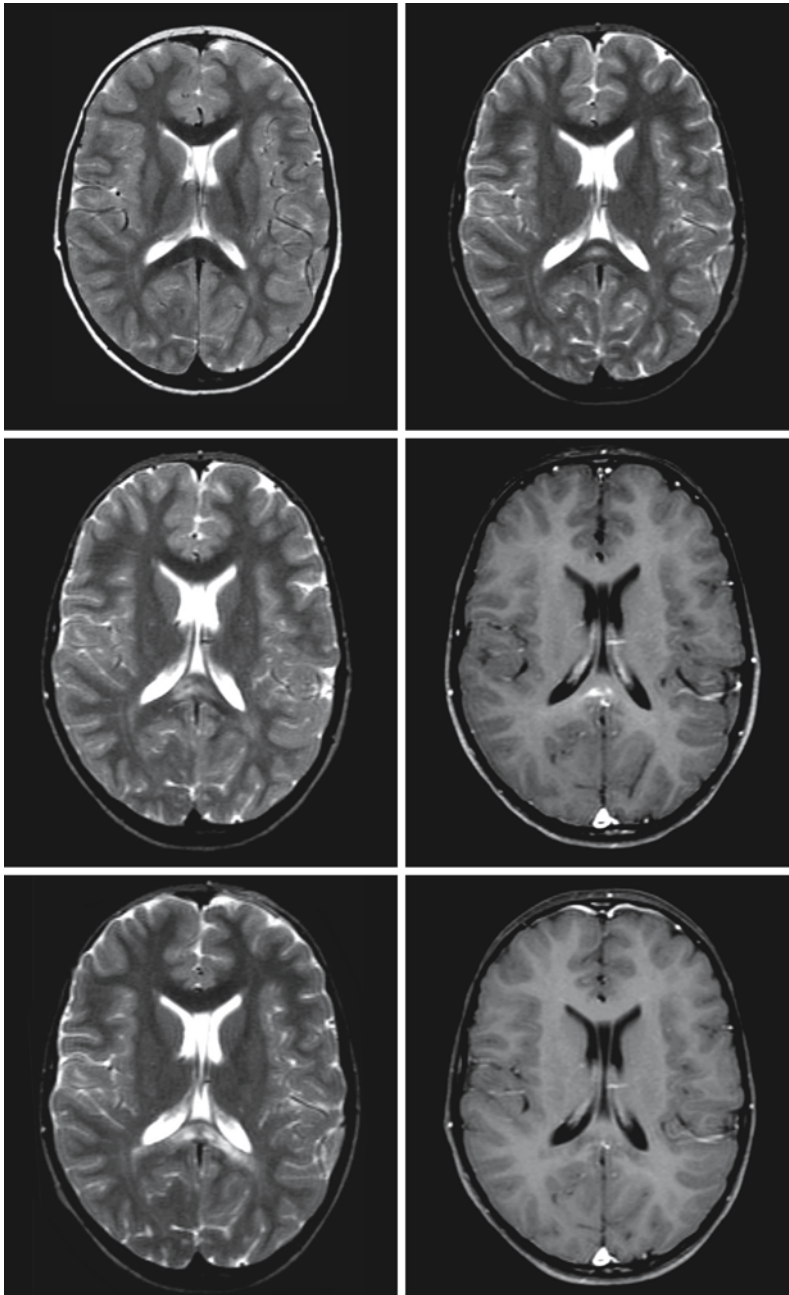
This boy is the younger brother of the patient shown in Fig. 21.1. He was diagnosed with the biochemical defect of XALD after his brother was diagnosed with the disease. He was monitored by MRI and MRS every 6 months and normal results were found (*upper row, left*). When he was 6 years old a lesion was found in the splenium of the corpus callosum (*upper row, right*), which had increased in size after 3 months (*middle row, left*). At that time contrast enhancement of the lesion was found (*middle row, right*). Bone marrow transplantation was performed soon after without major complications. The first MRI after the procedure showed some further progression of the lesion, but the lesion has been stable since and he is now 9 years old (*third row, left*). There is at most minimal contrast enhancement remaining. He is clinically intact
